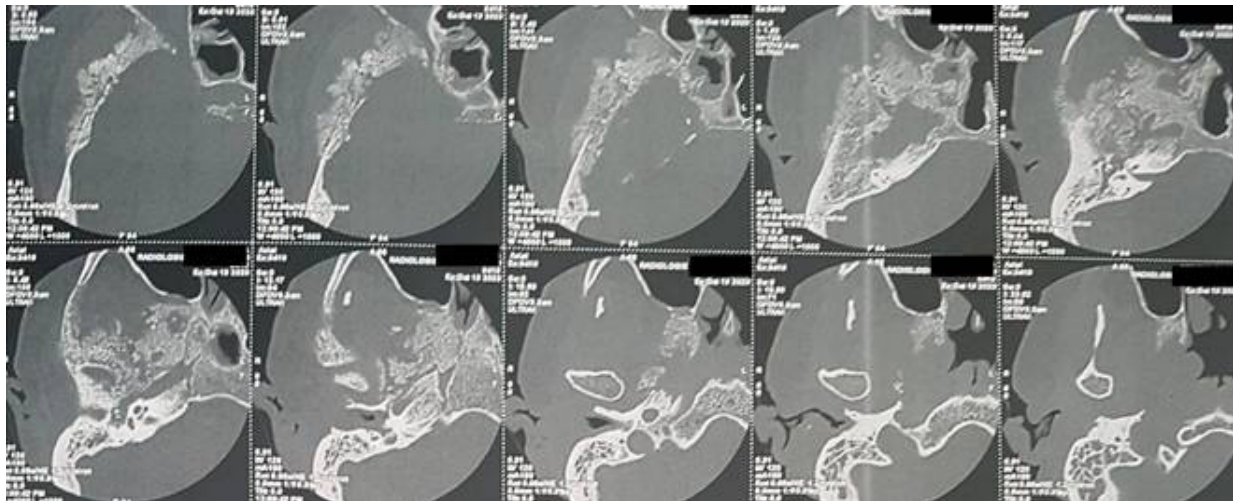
Temporal bone CT scan, axial sections: Massive petrous and mastoid bone destruction with preserved ossicular chain (red arrow) extended to the sphenoid bone and the zygomatic arch.
